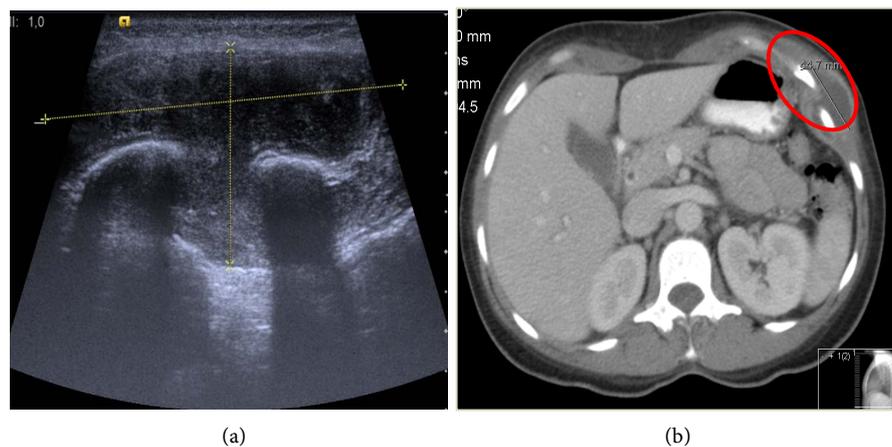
Abdominal Ultrasound and Computed Tomography scan respectively, revealing an abscess of the thoracoabdominal wall.
